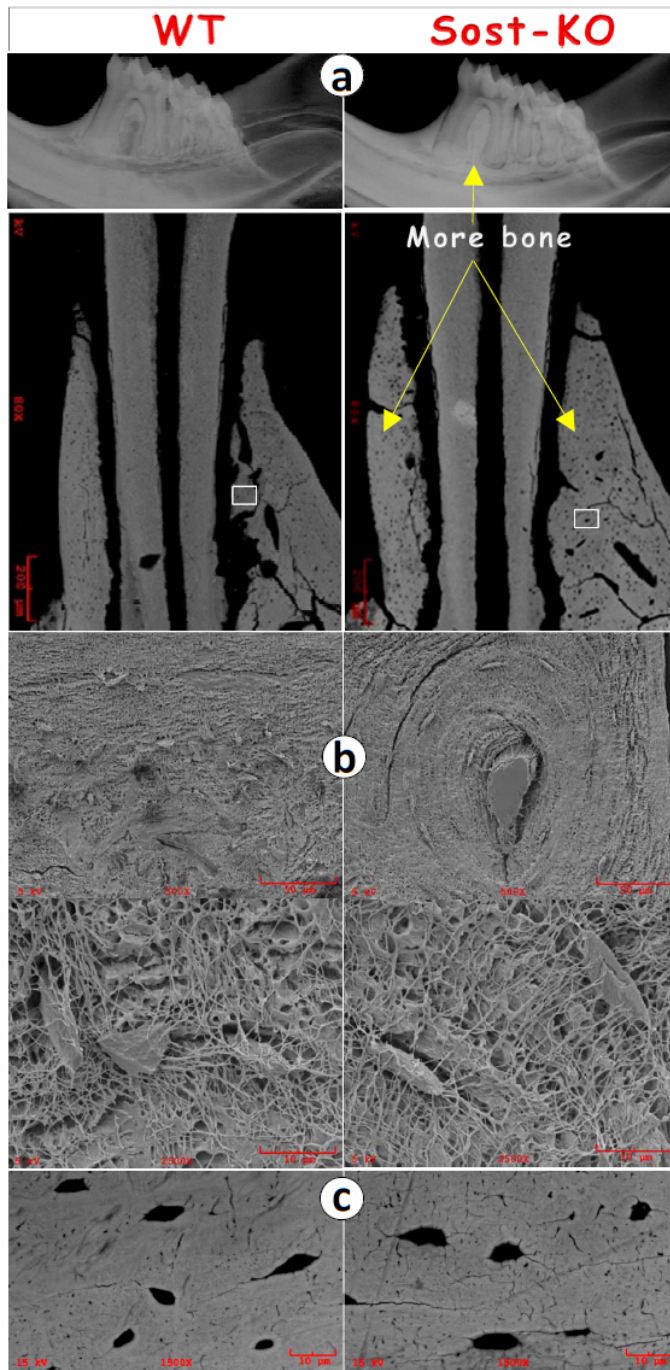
S3 *Deletion of Sost KO leads to changes of Ocy morphologies.*(a) Representative radiographs revealed an increase in Sost KO alveolar bone (*right*); (b) Acid
